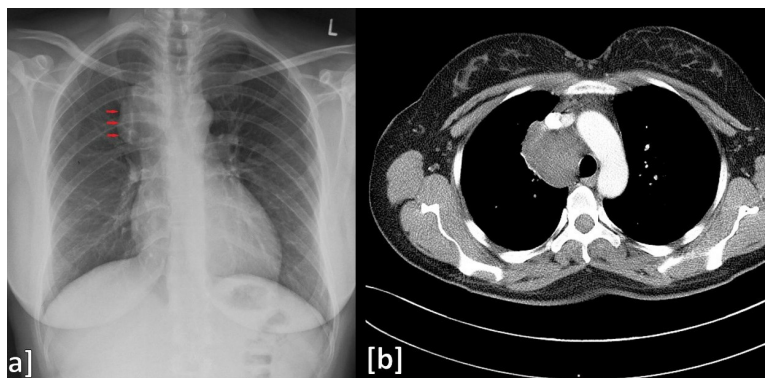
A) Chest x-ray of the 42-year-old woman showing an enlargement of the mediastinum. B) Axial computed tomography scan of her chest reveals a homogeneous mass at the right paratracheal region, extending towards the mediastinum.
